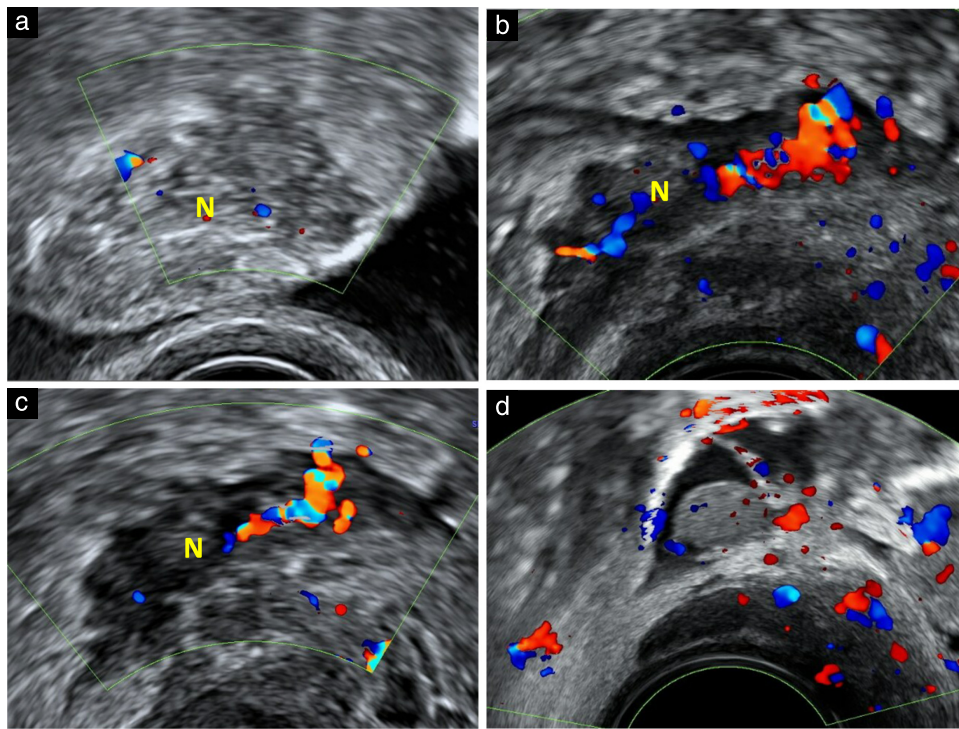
Transvaginal color Doppler images of endometriotic lesions. (a) Transverse section of anterior pelvic compartment demonstrating decidualized endometriotic nodule (N) in bladder wall at 10 weeks' gestation. (b,c) Longitudinal sections of posterior pelvic compartment demonstrating decidualized endometriotic nodule (N) in anterior muscularis of rectosigmoid colon at 12 (b) and 20 (c) weeks' gestation. (d) Tubular cystic structure in right adnexa containing anechoic fluid, incomplete septations and solid smooth walled papillary projection that demonstrated increased vascularity, in keeping with decidualized endometriosis involving hydrosalpinx.
